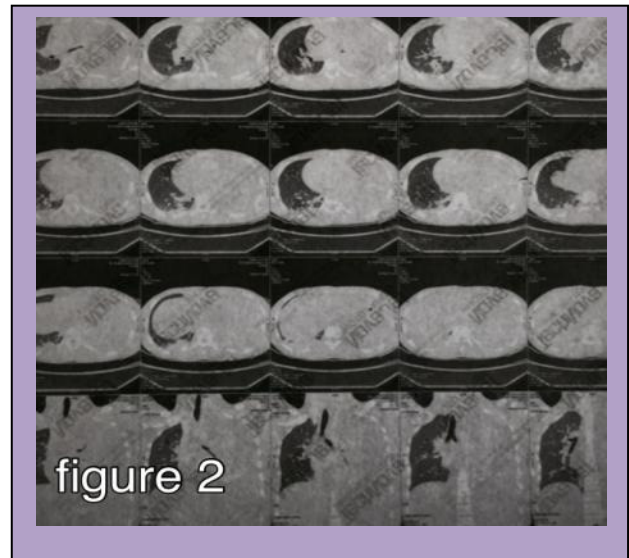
CT scan showing left lung collapse
